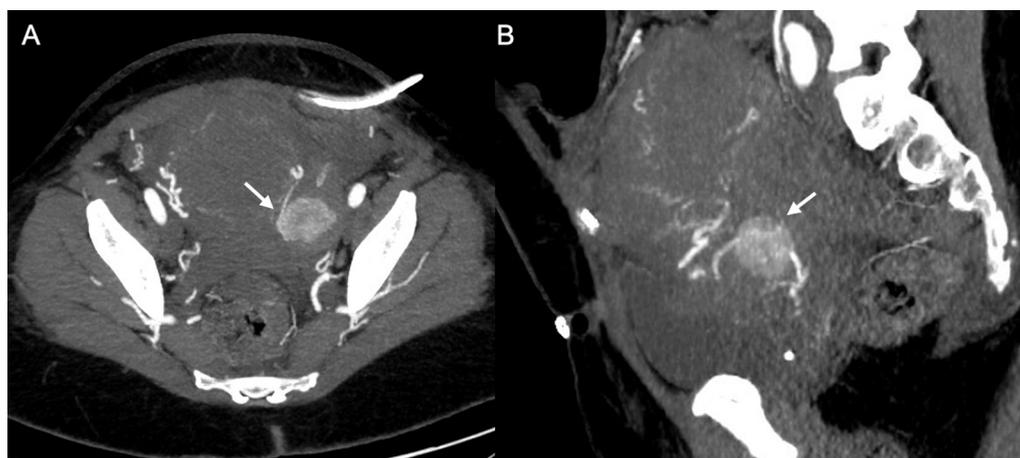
36-year-old woman who had a caesarean section and required re-operation within 24 h due to massive haemoperitoneum secondary to ruptured ovarian endometrioma. She was re-admitted with tympanic abdomen and severe pain. Suspecting active abdominal bleeding, CT angiography of the abdomen and pelvis identified a pseudoaneurysm of the left uterine artery (arrow) in the axial (A) and sagittal (B) maximum intensity projection reconstructions of the arterial phase. During admission, she suffered massive metrorrhagia, so it was decided to re-operate and a bleeding point was detected in the hysteroangiography. However, in view of the situation of haemorrhagic shock during surgery, a subtotal hysterectomy was performed. A few hours later, the patient had significant metrorrhagia with clinical repercussions and the haemodynamic option was finally chosen, which successfully embolised the uterine arteries. After that, her progression was favourable.
